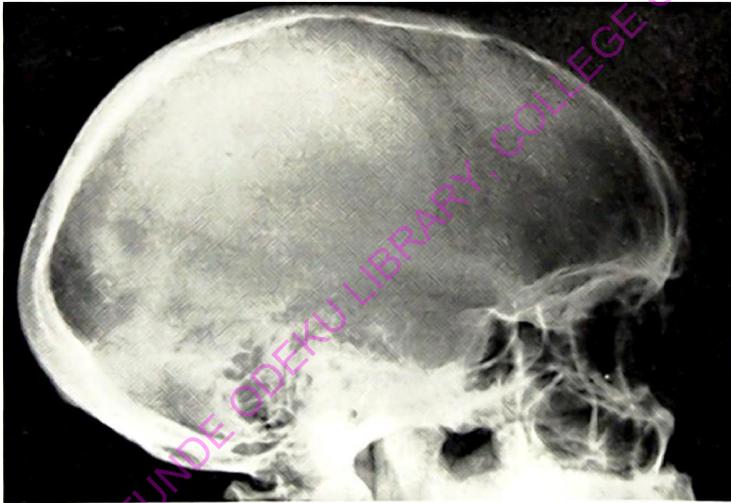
Arachnoid cyst of the sella turcica. Plain X-rays show an enlarged, eroded pituitary fossa.
